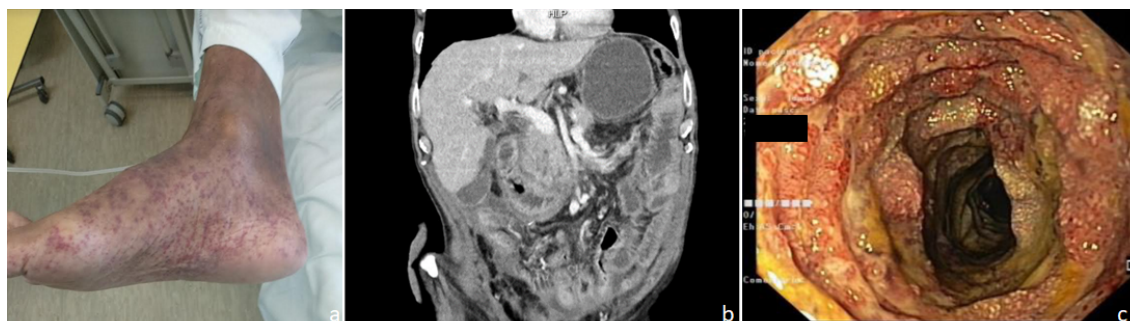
A. Purpuric cutaneous lesions involving predominantly the lower limbs. B. Abdominal CT scan revealing wall duodenal and jejunal thickening with an extension of 20 cm, with no changes in mesenteric vessels. C. Edema, hyperemia and diffuse erosions consistent with duodenal involvement with Henoch-Schönlein purpura.
